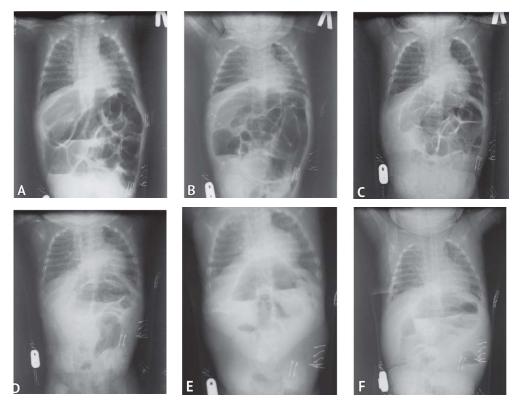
Plain X-ray scan of the abdominal cavity and chest over time: A – upon admission; B - 14 hours after hospitalization; C - 20 hours after hospitalization; C - 20 hours after hospitalization; C - 20 hours after hospitalization; F-64 hours after hospitalization
